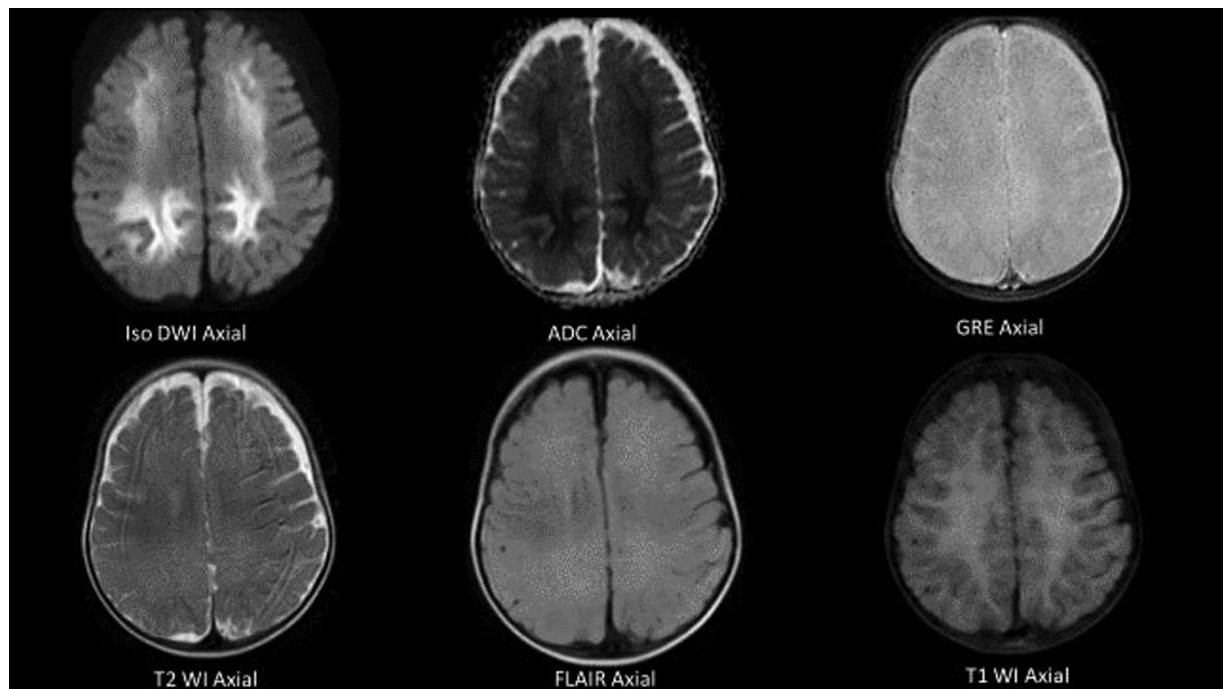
Bilateral symmetrical areas of subtle T2/fluid-attenuated inversion recovery (FLAIR) hyperintensities showing true diffusion restriction in subcortical and deep white matter of bilateral cerebral hemispheres as well as midbrain and pons, giving “bright tree appearance”—diffuse type of acute leukoencephalopathy with restricted diffusion.
